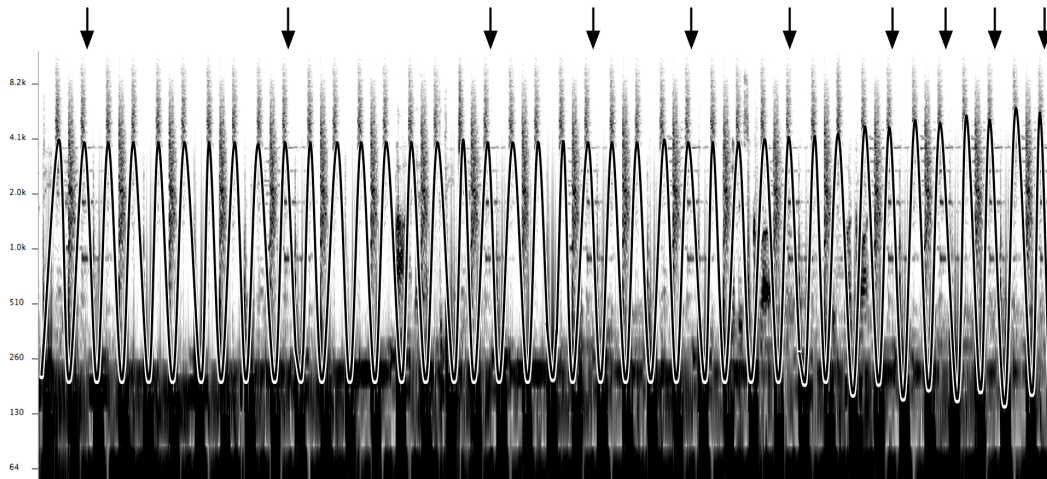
Sonogram with suggested movement curve for Romanthony's *Floorpiece*, 0:16–0:35, with arrows indicating repeated events.
